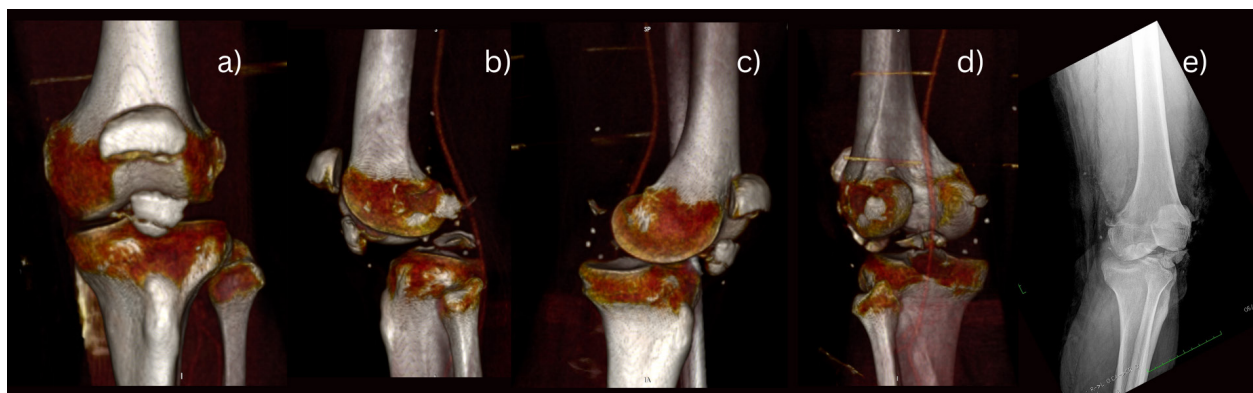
a) AP view of CT of the patient's knee pre-operatively b) Lateral view of CT of the patient's knee pre-operatively c) Medial view of CT of the patient's knee pre-operatively d) Posterior view of CT of the patient's knee pre-operatively e) AP X-ray of the patient's left limb pre-operatively
